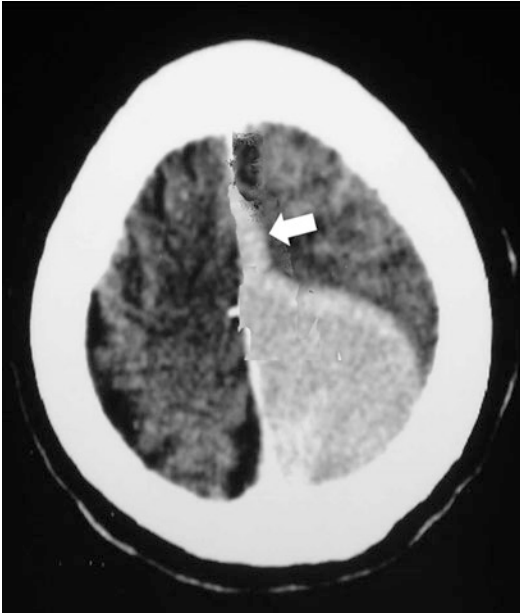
Contrast-enhanced CT brain scan showing a typical meningioma arising from the falx cerebri and manifesting an enhancing dural tail (the white arrow)
